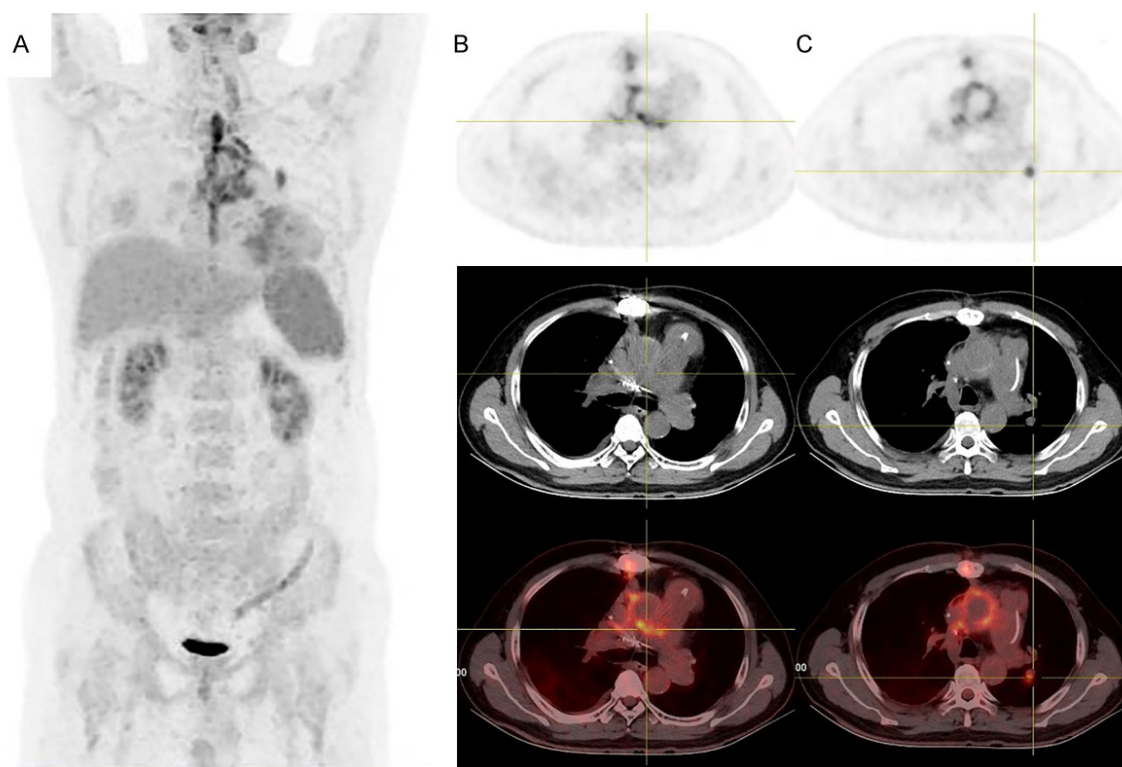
^{18}F -FDG PET/CT images after the 2nd surgery. A. The MIP image demonstrated diffused hypermetabolic lesions around the ascending aorta, aortic arch, the main trunk of the right pulmonary artery, and the upper lobe of the left lung near the hilum; B. The transverse images demonstrated increased FDG uptake in the soft tissue (SUVmax = 8.2); C. The transverse images demonstrated a soft tissue nodule in the upper lobe of the left lung near the hilum with a higher FDG uptake (SUVmax = 6.1) at about 1.1 cm \times 1.3 cm in size.
